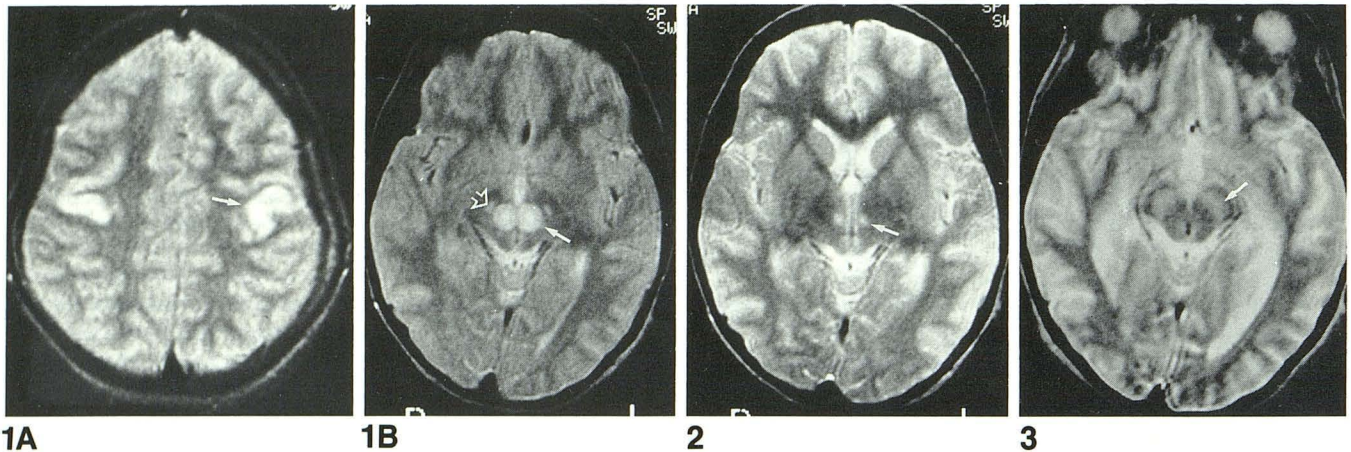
A, T2-weighted images (2000/90) showing discrete symmetrical lesions of increased signal intensity at the cortical-subcortical junction of the frontoparietal region (*arrow*) (day 7).
